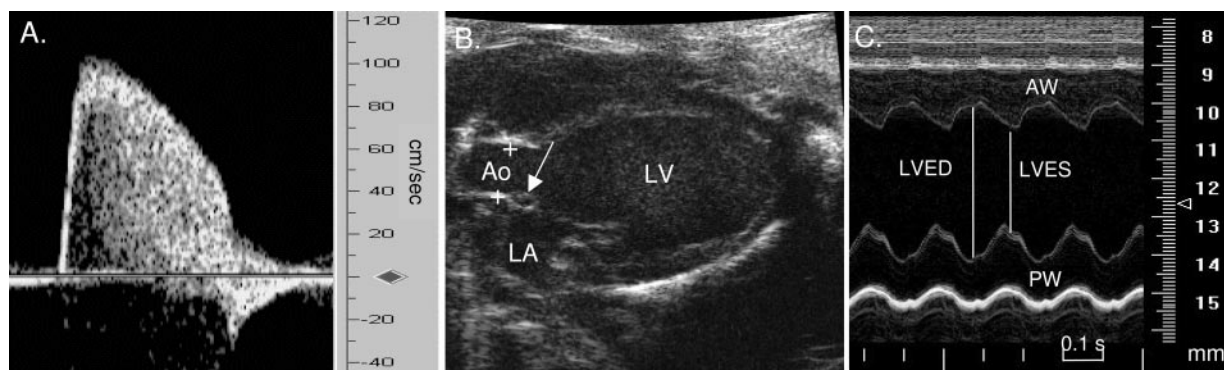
Ultrasound evaluation of cardiac structure and function. A, Doppler blood velocity waveform recorded from the ascending thoracic aorta. B, Long-axis view of the left ventricular outflow tract showing aortic calipers and open valve (arrow). C, M-mode image of the left ventricle. Ao indicates ascending aorta; AW, anterior wall; LA, left atrium; LV, left ventricle; LVED, left ventricular end-diastolic dimension; LVES, left ventricular end-systolic dimension; PW, posterior wall.
